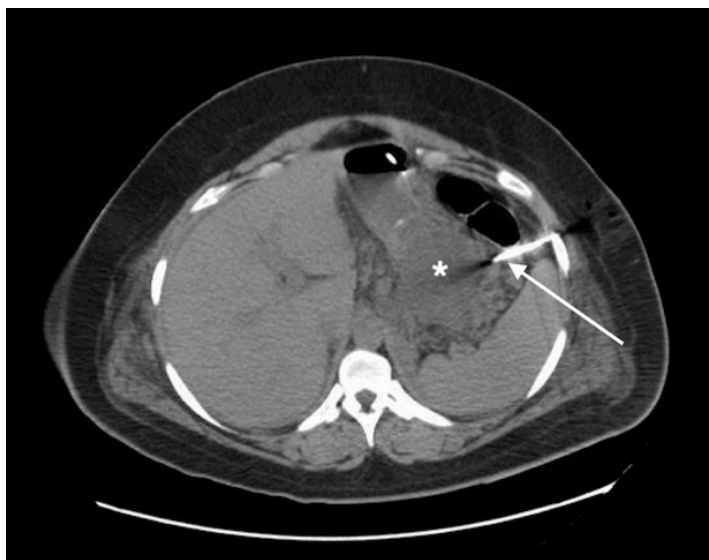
CT-guided drainage performed on day 7 of admission. A 6.6 cm fluid collection (*) superior to the tail of the pancreas was aspirated using an 18 G Chiba needle. The needle is represented by the linear, metallic-density structure inserted percutaneously into the left upper quadrant (white arrow). A total 130 cc of brown turbid fluid was obtained.
